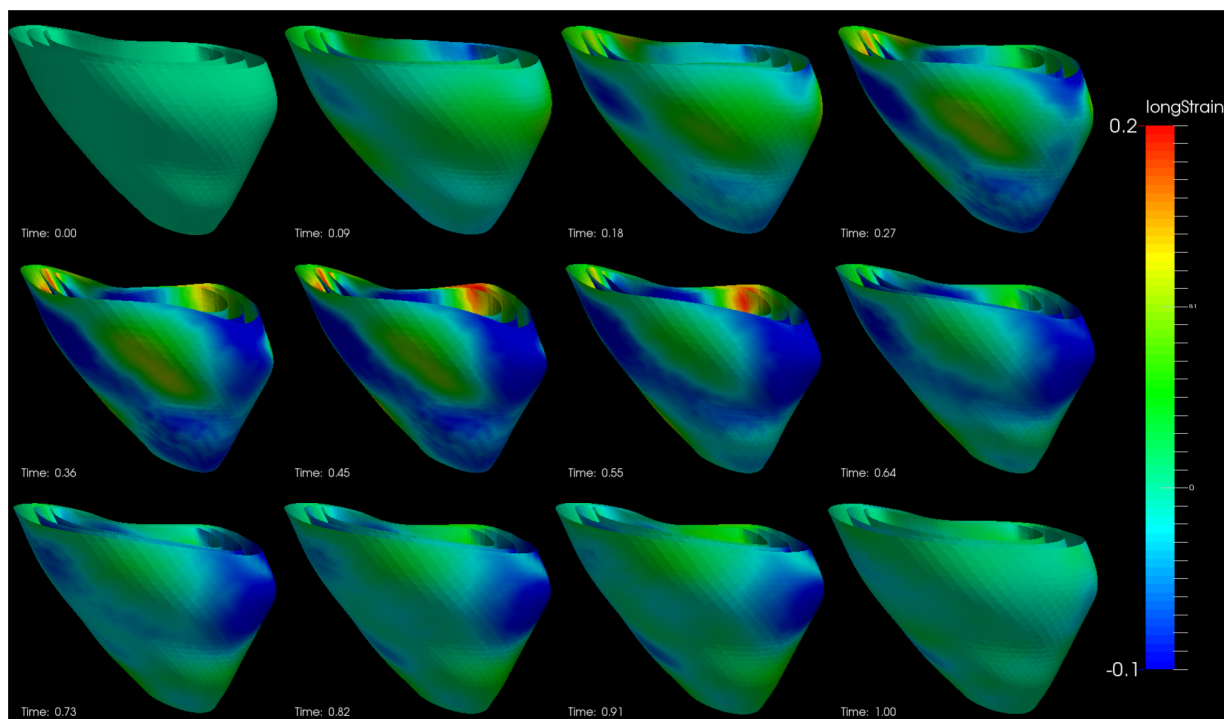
Longitudinal strain of an example echocardiography sequence varying with time in a cardiac cycle. (The cardiac time is normalized between 0 and 1.)
